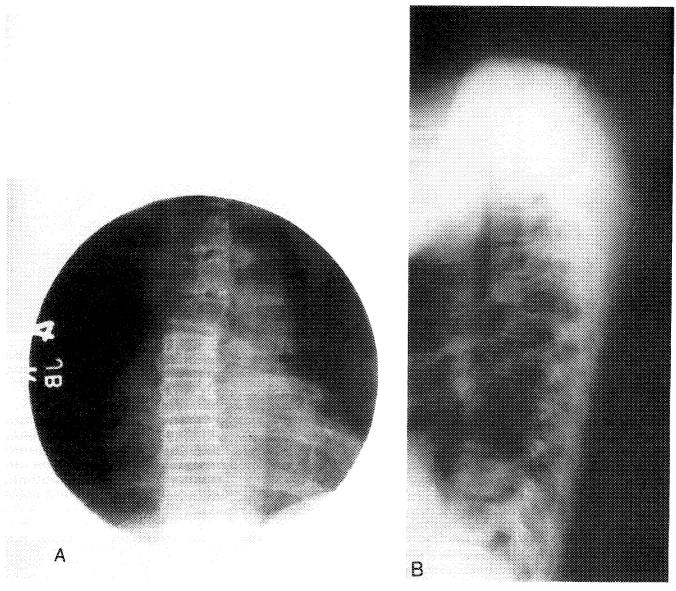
Anteroposterior (A) and lateral (B) plain radiographs demonstrate slight collapse and anterior translation of the fifth thoracic vertebra with erosion of the right pedicle.
